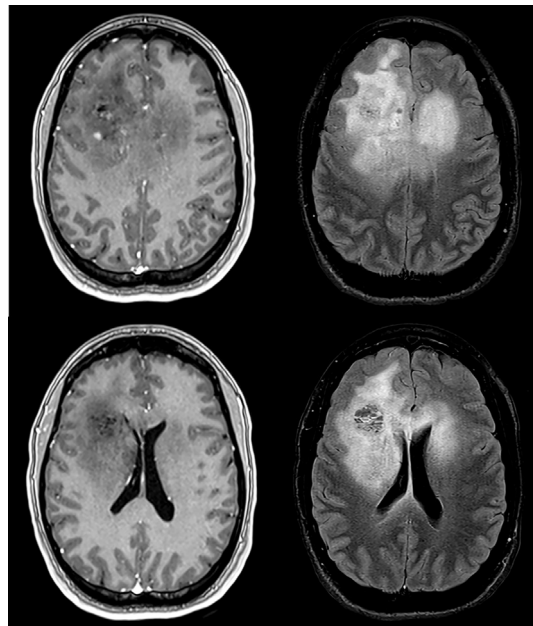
Representative slides of the patient's initial diagnostic imaging study. Contrast-enhanced T1-weighted (left top and bottom) and fluid-attenuated inversion recovery (right top and bottom) magnetic resonance imaging.
